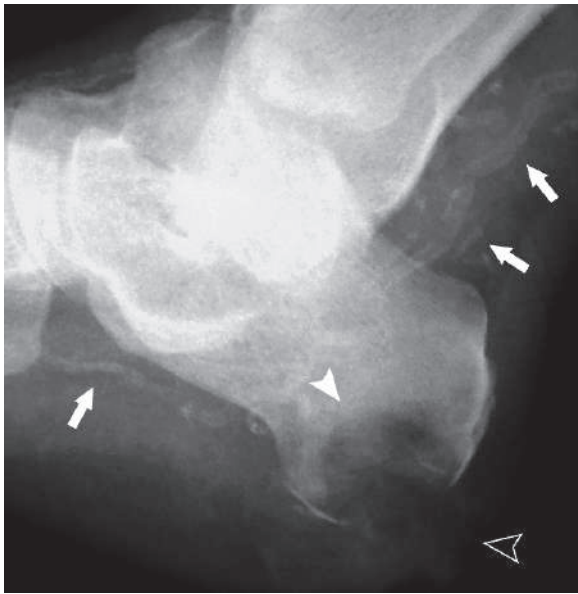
A lateral plain radiograph of a patient with severe diabetic foot shows calcaneal ulcer (*hollow arrowhead*), osteomyelitis causing bone resorption and necrosis (*solid arrowhead*), and calcified arteries due to macroangiopathy (*arrows*)
